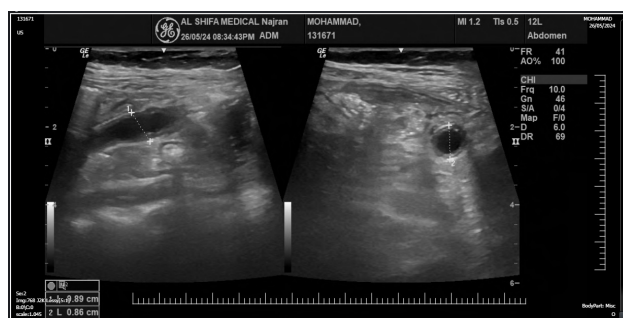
A long, oedematous, blinded lobe structure was seen by pelvic-abdominal ultrasonography.
